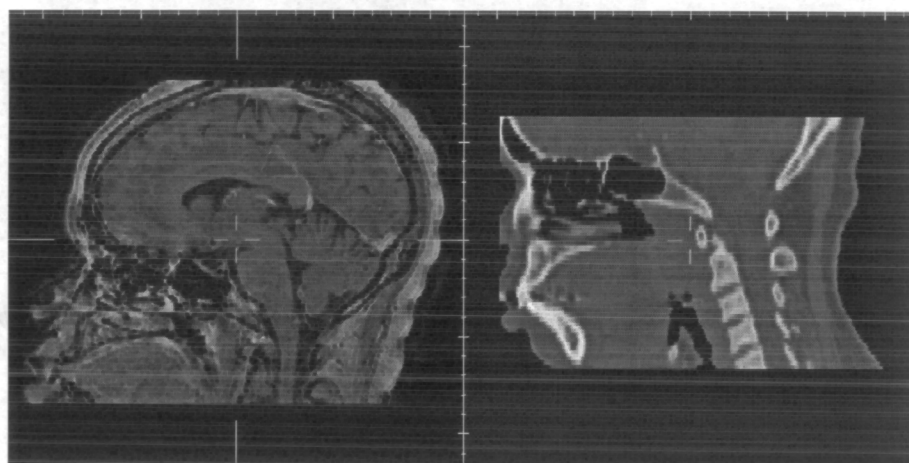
Example sagittal slices through MR (left) and CT (right) images of patient N showing acquisitions of the skull base including a significant portion of deformable structures in the neck and mouth.
